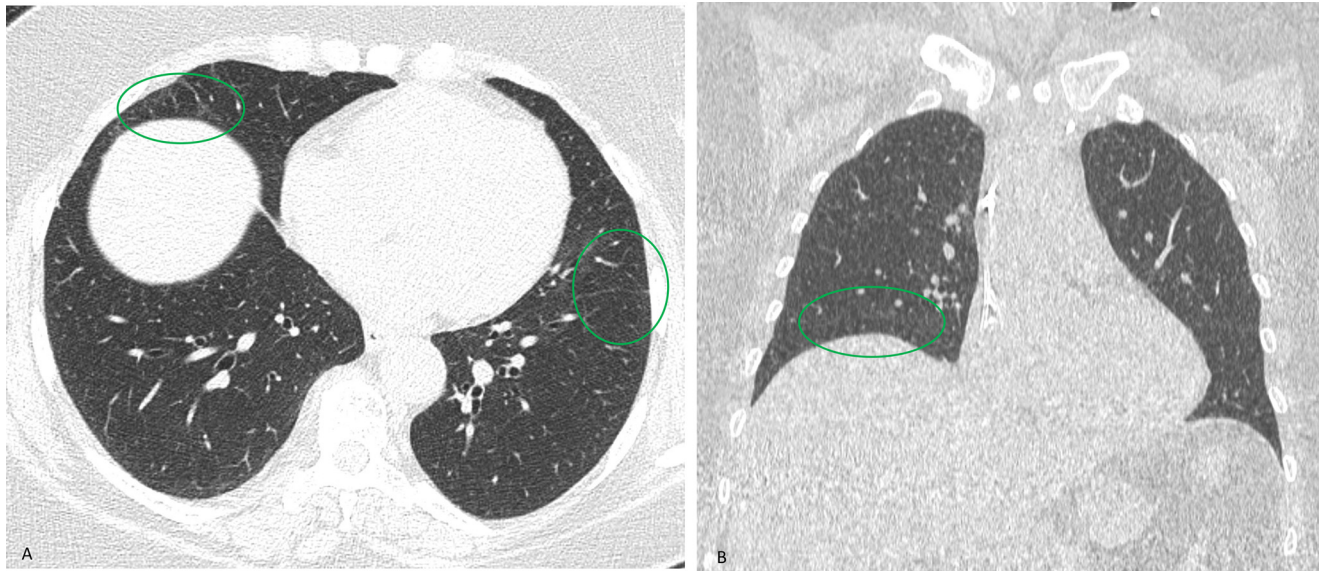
(A) Axial and (B) coronal CT images of the chest without contrast performed 27 days later demonstrated interval resolution of ground glass opacities (circled areas).
